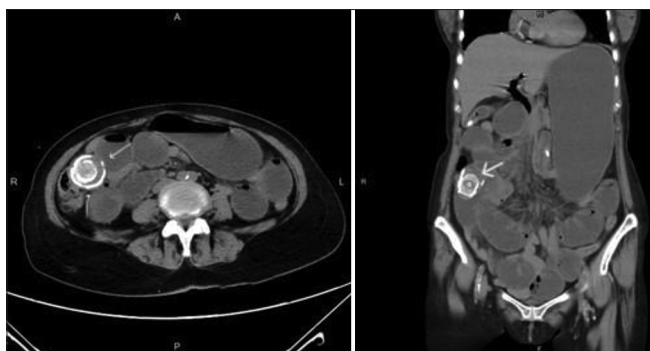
Computed tomography revealing the presence of calcified stones (white arrow) in the bowel with ileus
